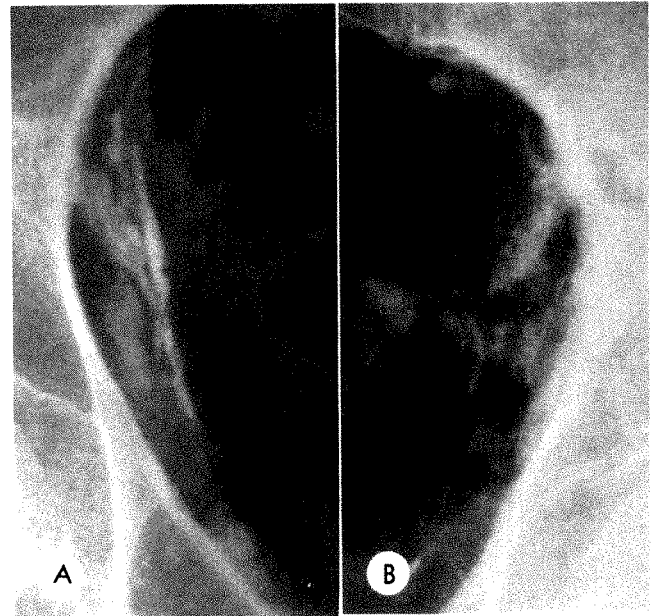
Radiographs of one patient showing thin linear calcifications on right (A) and periosteal reaction with globular thickened calcifications on left (B).
